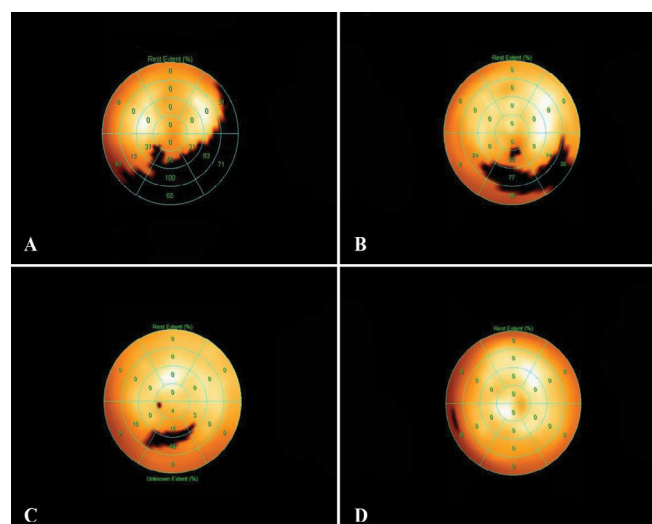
Myocardial scintigraphy of a 71-year-old male patient after CABG + YurLeon before surgery (A), seven days after revascularization (B), three months after revascularization (C), twelve months after revascularization (D).
